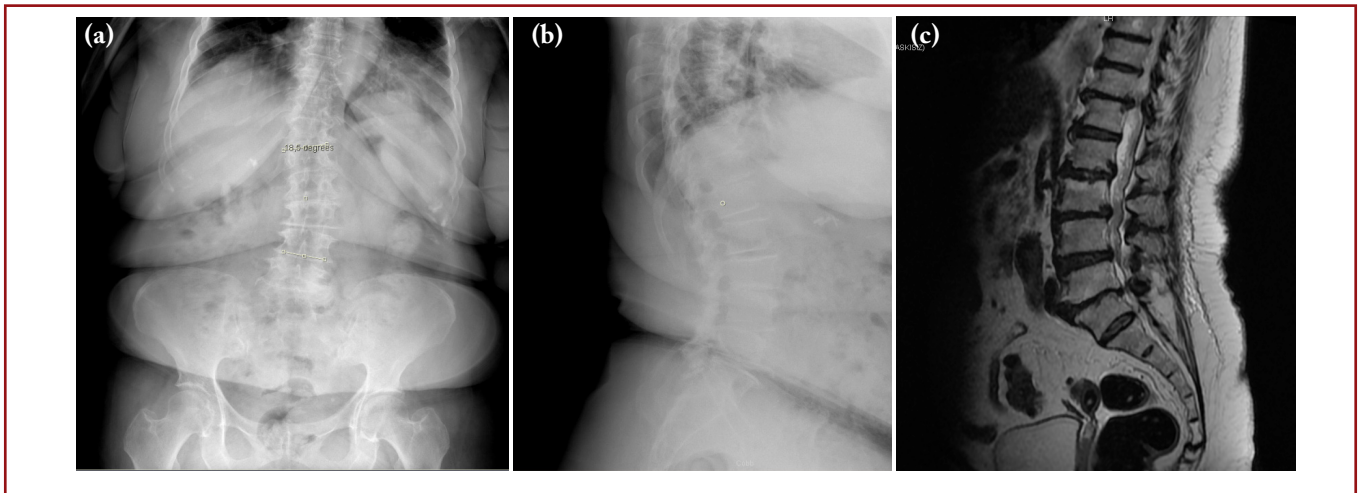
74 year old female with radicular symptoms and back pain. a. PA roentgenogram of the patient with degenerative scoliosis. T12-L3 cobb angle was 18 degree. b. Lateral roentgenogram of the patient showing osteophyte formation and disk height reduction. c: Sagittal MRI of the patient showing disk degeneration , modic changes and spinal stenosis.
